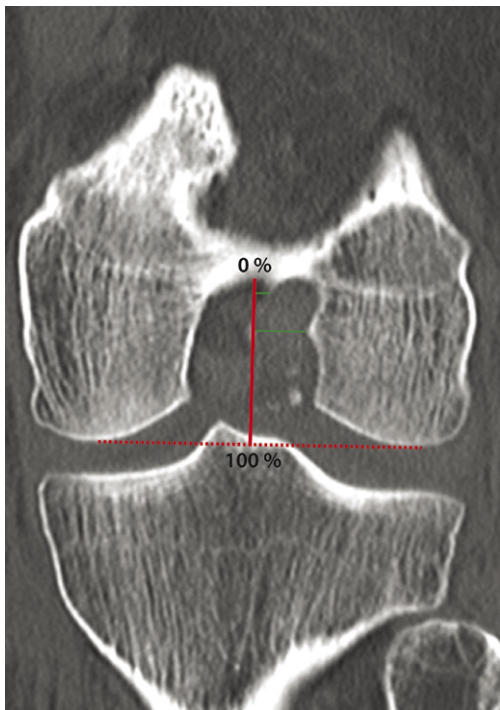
Measurement performed according to Hoser of the femoral tunnel on the coronal CT reconstruction. The tunnel is measured in comparison to the line perpendicular to the most distal points of the femoral condyles. The measurement is compared to the line from the intracondylar roof to the distal femoral condyles.
